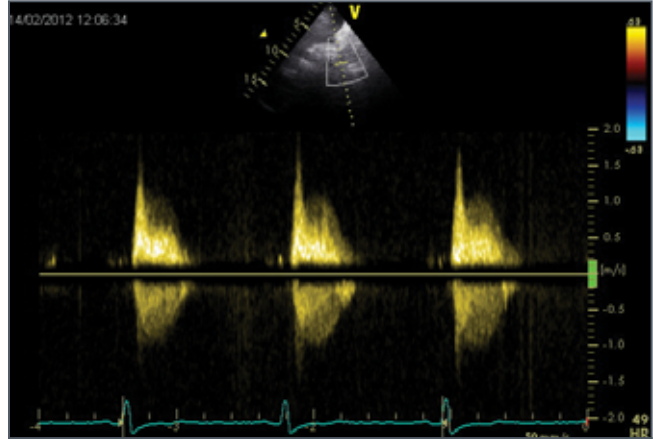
CW Doppler through the descending thoracic aorta on a suprasternal long axis view.
